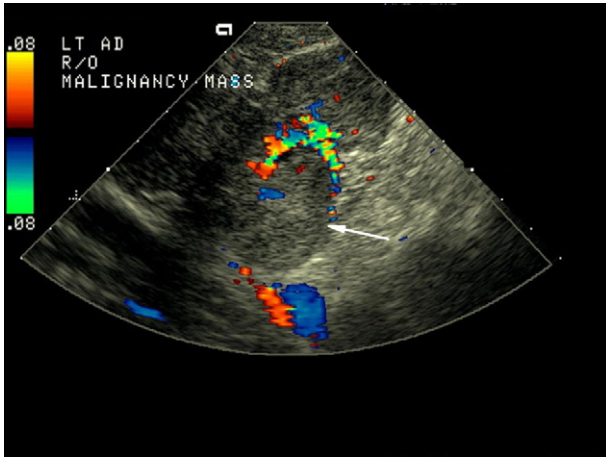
Ultrasonography. The left adnexa was enlarged due to a tumor with a sausage-like appearance, approximately $6 \times 4 \times 3 \text{ cm}^3$ in size (white arrow). Prominent central flow was noted.
